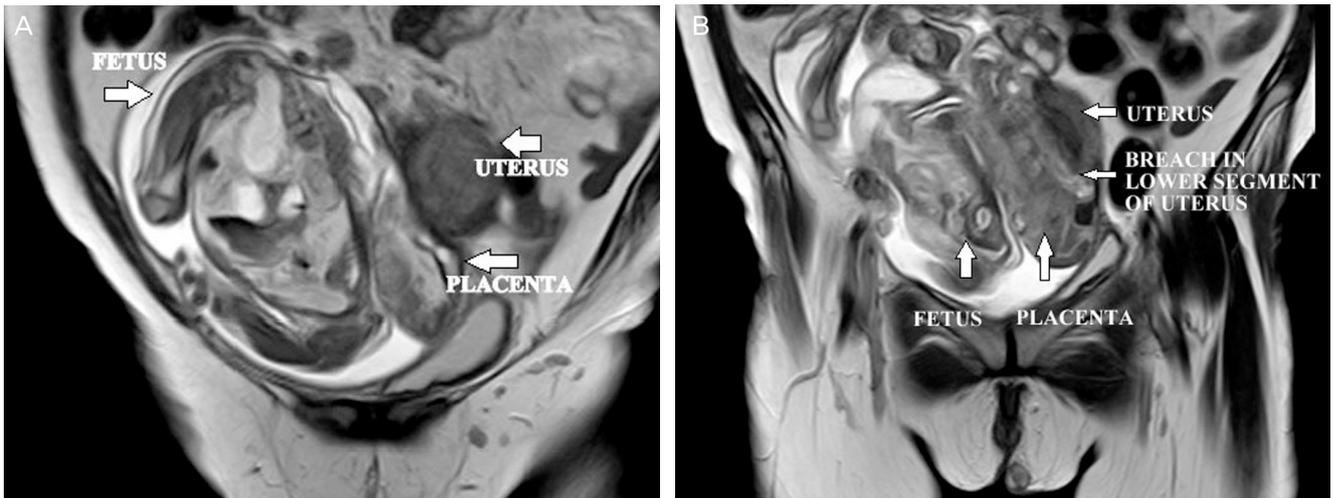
(A) Magnetic resonance imaging picture of pelvis showing uterus on left side and fetus on right side. Placenta medial to fetus. (B) Magnetic resonance imaging picture of pelvis showing a breach in the lower segment of uterus opening into the fetal sac.
